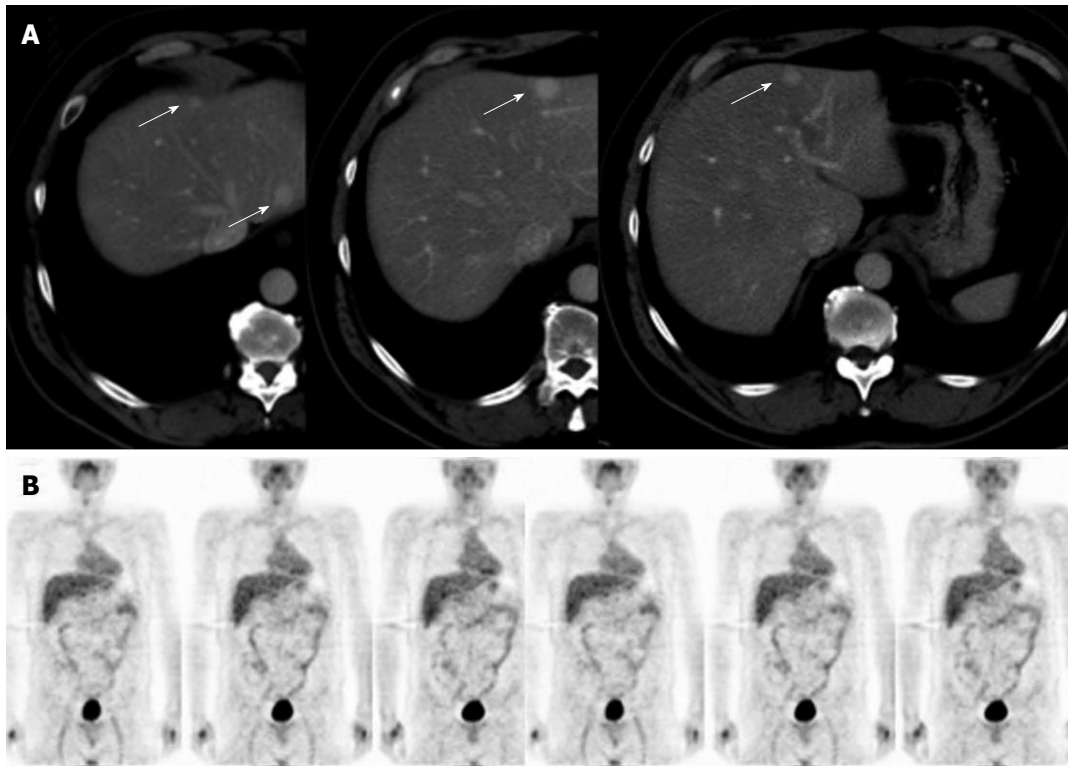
Radiological imaging of case 2. A: The abdominal contrast-enhanced computed tomography showed multiple focal liver lesions (arrows); B: The fluorodeoxyglucose-positron emission tomography scan did not show any pathological uptake of the trace.
